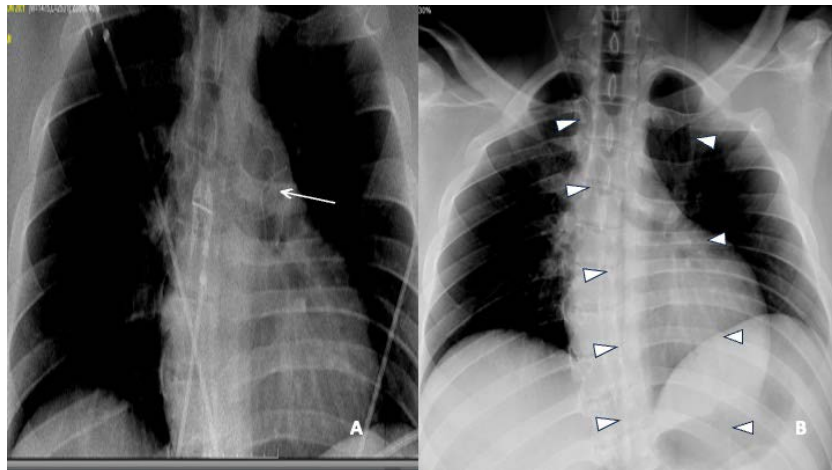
Comparison of chest radiograph (A) with prior ventriculoperitoneal shunt series chest radiograph (B) demonstrating a curvilinear density coiled and projecting over the pulmonary artery shadow.
